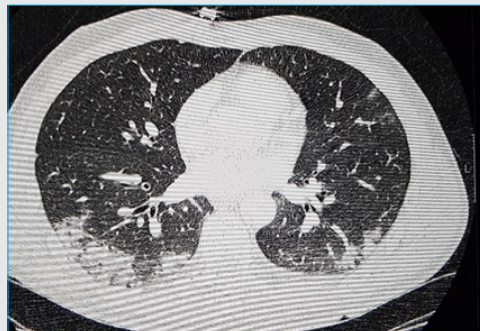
Axial section of a CT chest of a patient with COVID-19 show bilateral confluent opacities seen on the periphery of the lower lobes.
